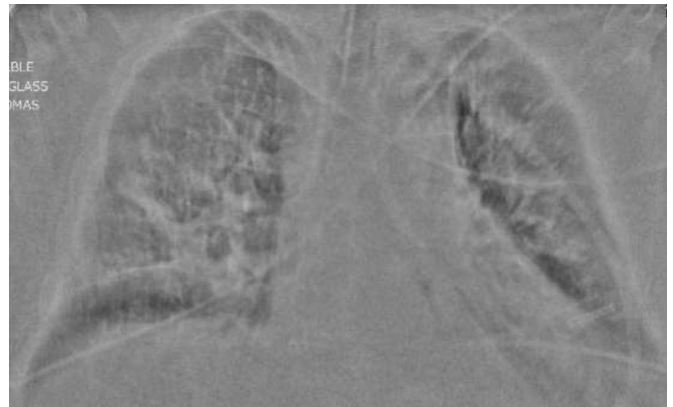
Plain film of the chest before transfer from our institution to a skilled nursing facility. Note the stable to improved right middle and lower lung airspace opacities.
